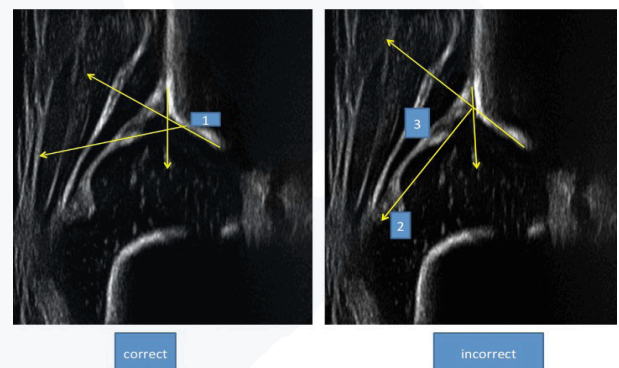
Left sonogram: Checklist I and checklist II are ok. Measurement lines are correct. right: checklists are ok too, but mistakes: bony roof line is not tangential to the bone, it cuts the echoes (=bone!). cartilage roof line is wrong: It does not come from the bony roof (= "concavity to convexity") (1), it comes incorrectly from the crossing point from the other lines and goes to the synovial fold (2) instead to the middle of the labrum (3).
